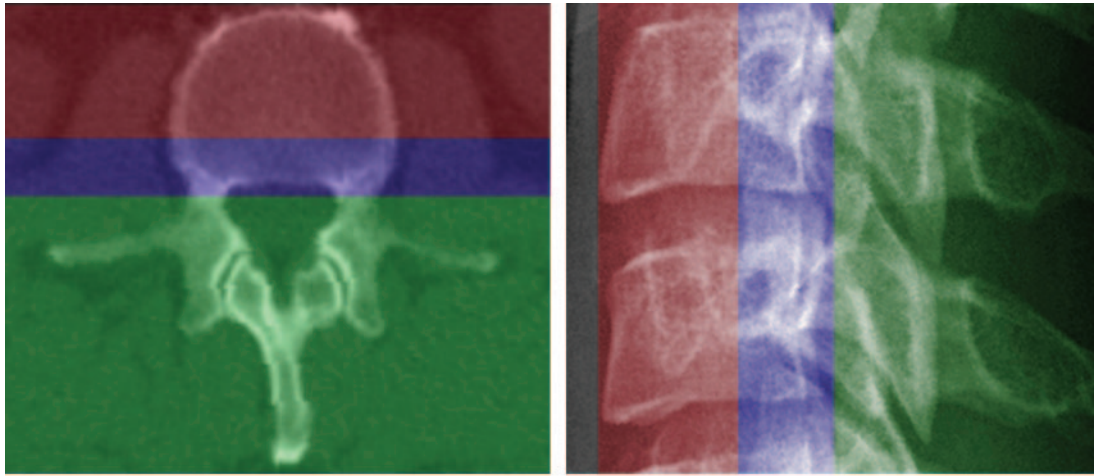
The three columns of the spine. Axial CT image (a) and lateral radiograph (b) with color overlay show the anterior (red), middle (blue), and posterior (green) columns in a normal patient.
